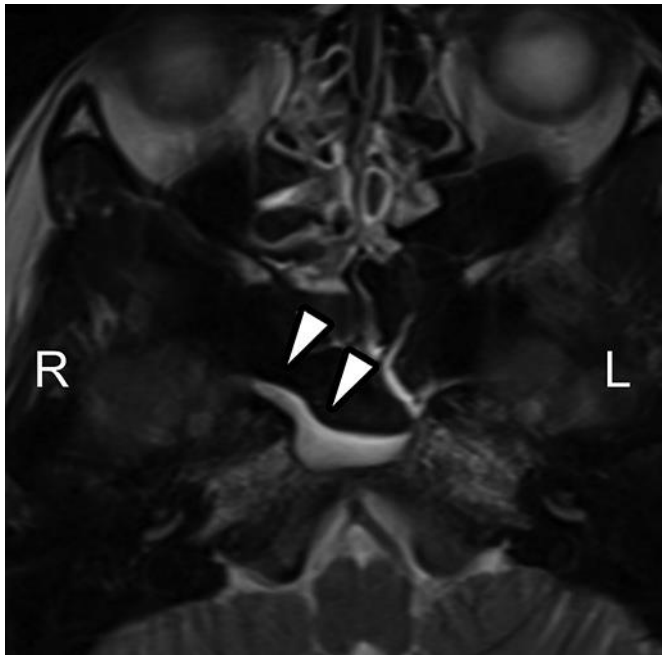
Axial T2-weighted head MR image on the day following initial onset. This MR image reveals acute sphenoid sinusitis, including fluid (arrowheads).
